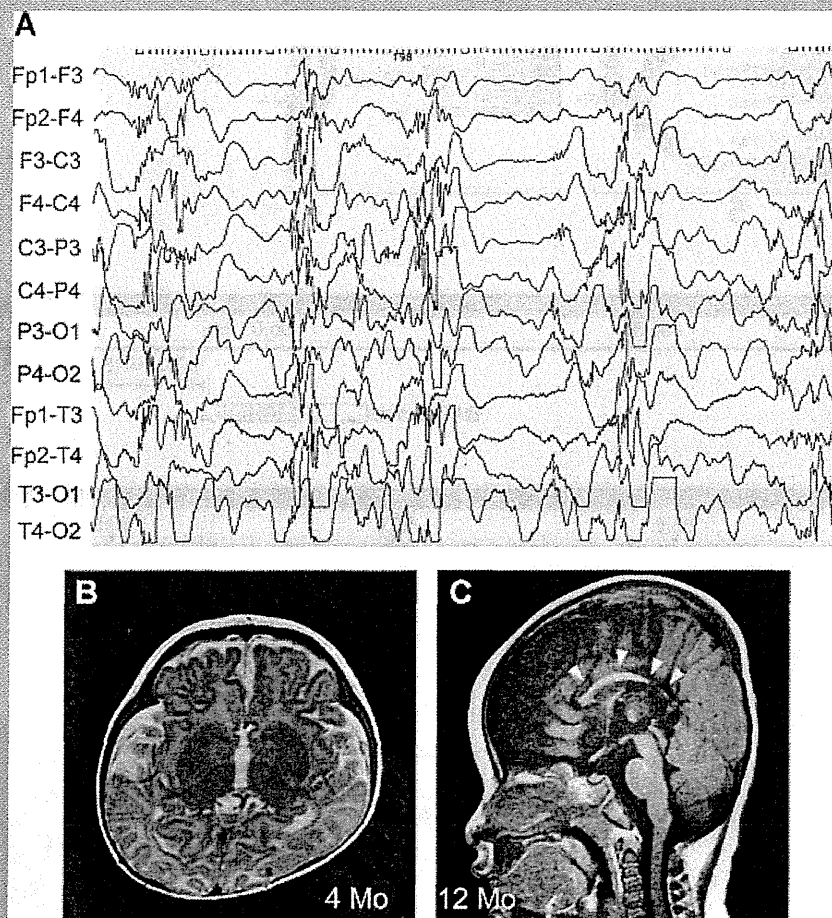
EEG and brain MRI in the patient. A: Interictal sleep EEG at 4 months demonstrated diffuse or multifocal polyspikes or sharp waves concomitant with irregular high-voltage slow wave. Desynchronization lasting for 1–2 sec can also be seen predominantly in bilateral frontal area. B,C: Brain MRI of the patient at age of 4 months (B) and 12 months (C). T2-weighted axial (B) and T1-weighted sagittal (C) images showed normal cortical brain structure except for hypoplastic corpus callosum (arrowheads), especially in genu and splenium.
